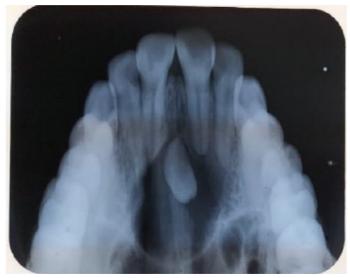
Occlusal radiograph of the lesion
